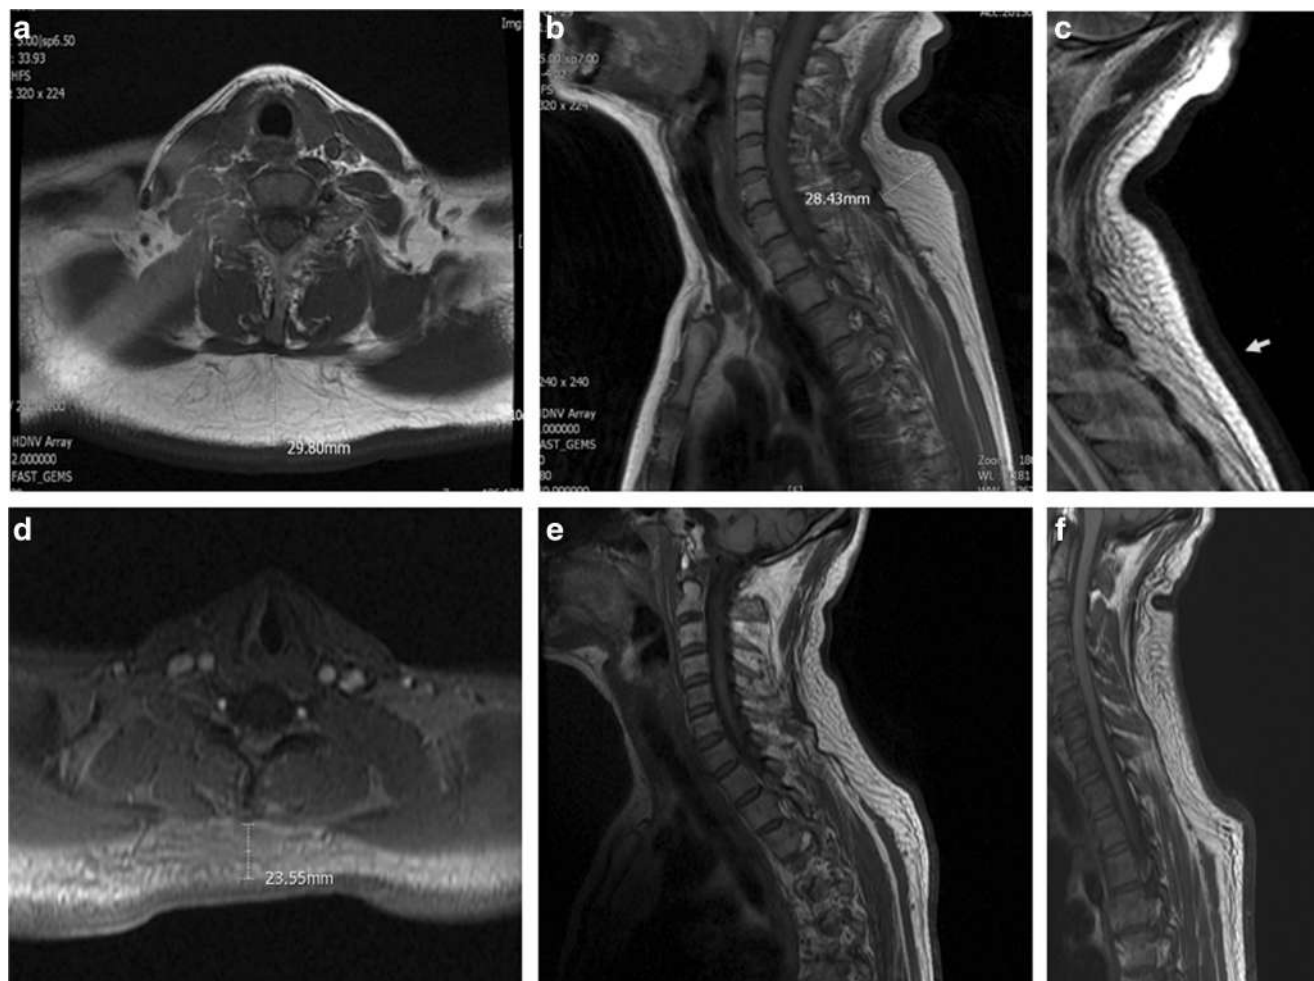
a, b Skin and subcutaneous tissue thickness in neck and upper back of the DS and non-DS patients. a-b Hyper-intense signals were apparent on T2-weighted magnetic resonance imaging in DS patients. c
